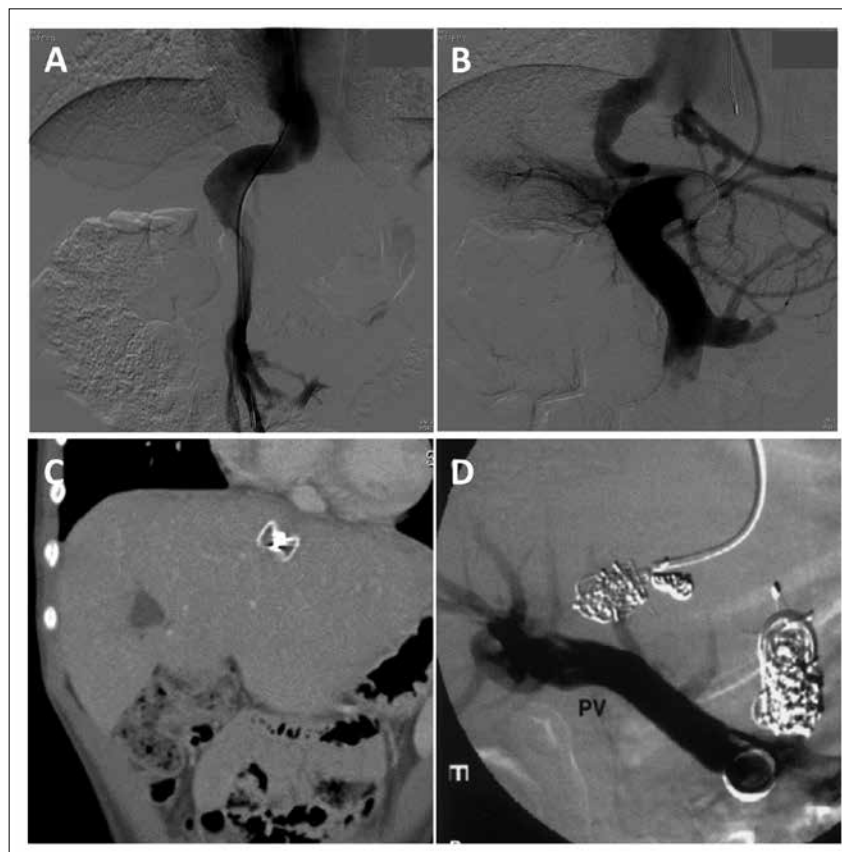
Endovascular closure of congenital portosystemic shunts. Patient 1: (A) Venogram demonstrated a large fistula between the portal vein and right atrium. (B) Intrahepatic branches of the portal vein were visualised following balloon occlusion of the shunt. (C) Postoperative computed tomography scan showing an Amplatzer plug which successfully occluded the shunt. Patient 2: (D) Coil embolisation is an alternative endovascular modality for shunt closure. (Reproduced here with permission from Lautz TB, Superina RA. Congenital anomalies of liver vasculature. In: Davenport M, Superina RA, Heaton ND, eds. *Surgery of the Liver, Bile Ducts and Pancreas in Children*. 3rd ed. Boca Raton: CRC Press, 2017:267-278.
